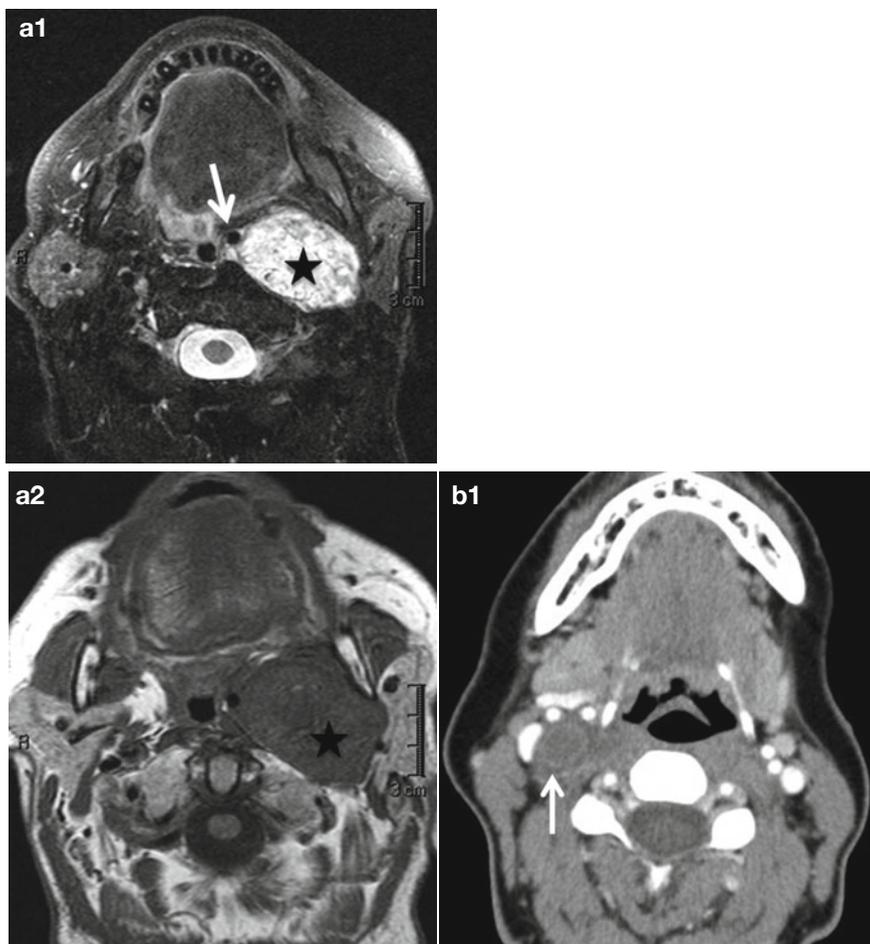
(a) Vagal schwannoma. Axial T2 and T1 (a1 and a2) MR images of a left carotid space vagal schwannoma, which is T2 hyperintense, with heterogeneous peripheral enhancement and central necrosis. (not shown here). The mass displaces the internal carotid artery anteromedially (*arrow* in a) and completely effaces the internal jugular vein. (b) Sympathetic trunk schwannoma. CT (b1) and MR images (b2 and b3) of a hypodense right carotid space well-defined lesion, which is T2 hyperintense and has a tubular configuration, best appreciated on the coronal post-contrast sequences (*arrow* in b3). The internal and external carotid branches are displaced anteriorly, while the internal jugular vein is displaced laterally. On resection, this was a schwannoma arising from the sympathetic trunk. (c) Glomus vagale. Sagittal and axial post-contrast MR images (c1 and c2) of a left-sided glomus vagale paraganglioma, as a heterogeneously enhancing mass in the left carotid space. This lesion extends superiorly towards the jugular foramen (*arrow* in c2) and shows a focal blush (*arrow* in c4) on the left common carotid angiogram. These lesions usually arise within 1–2 cm below the skull base. (d) Carotid body tumor. Intensely enhancing left carotid space mass lesion (d1, d3, d4, d5), with small flow voids (d2) along with the characteristic location at the carotid bifurcation, splaying the internal and external carotid branches on the MR angiogram (d4) and the catheter angiography (d5), consistent with a carotid body paraganglioma
